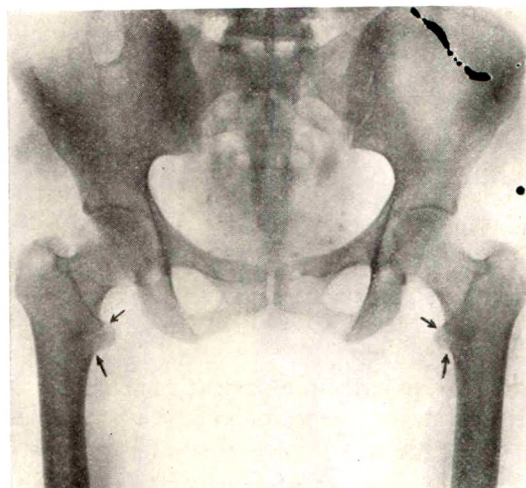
Roentgenogram taken in July, 1927. Note the pseudo-fracture at the lesser trochanter extending towards the shaft, bilateral and symmetrical. This condition was overlooked in first examination at another hospital.
